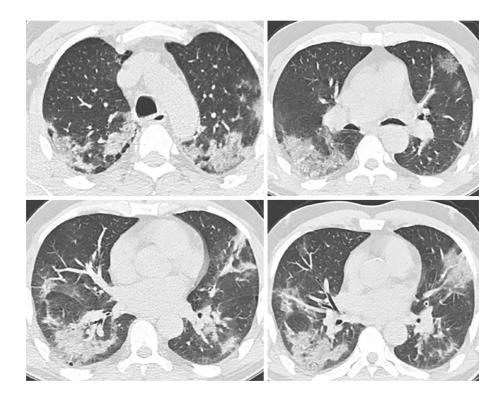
High resolution computed tomography images of coronavirus disease 2019 patient showing the bilateral ground-glass opacities and consolidations.
